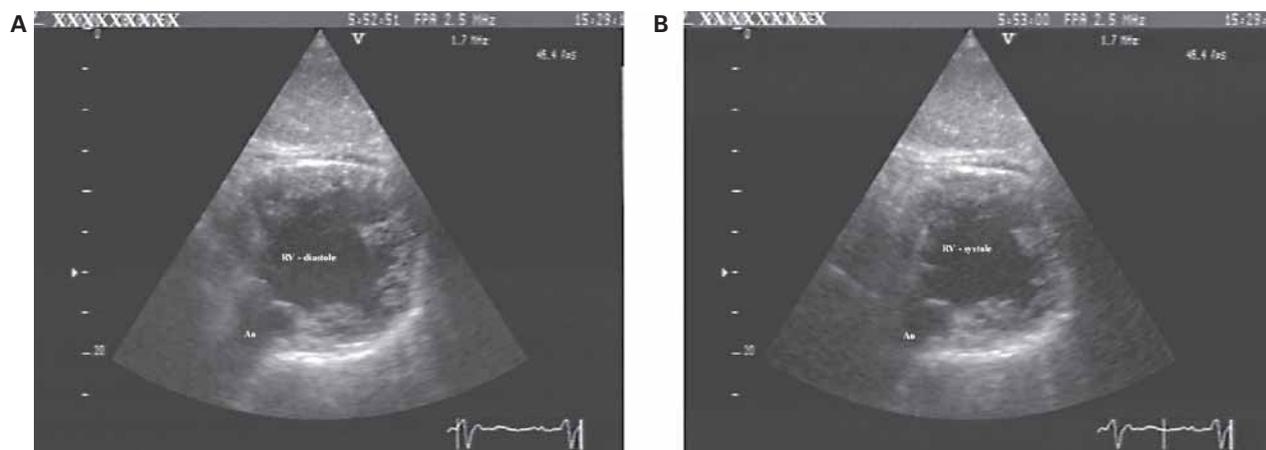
Echocardiographic assessment of the right ventricular area change from the subcostal window, enabling simultaneous demonstration of the entire right ventricular cavity (both inflow and outflow tracts). Right ventricle (RV) in the end-diastolic (A) and in the end-systolic (B) frames.
